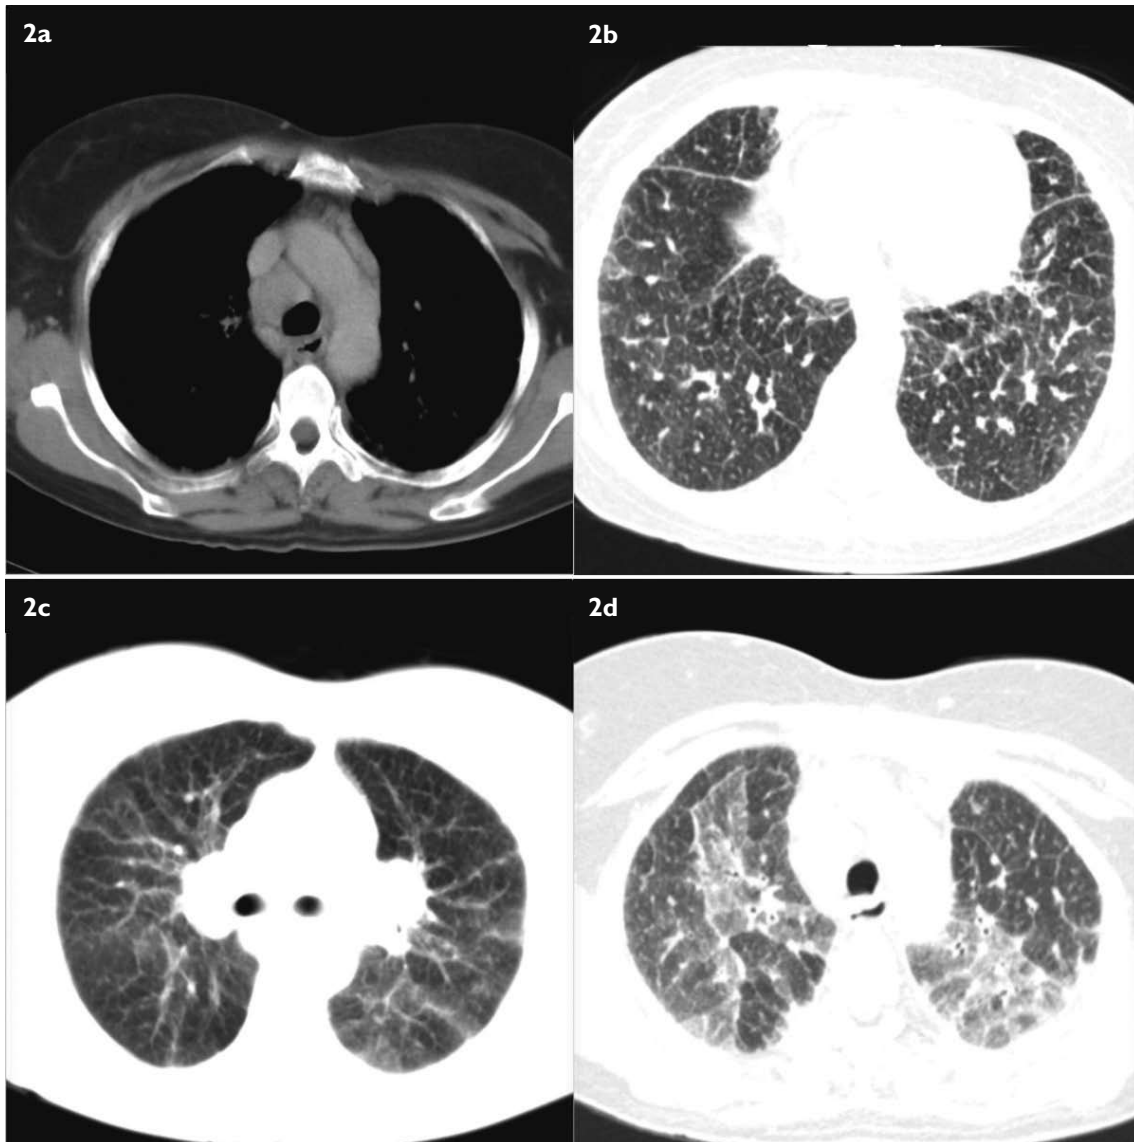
Axial CT images of the chest show (a) enlarged paratracheal, subcarinal, and hilar lymph nodes; (b) bilateral interstitial fibrosis; (c) multiple bilateral diffuse nodular opacities; and (d) ground glass opacities with nodular lesion.
